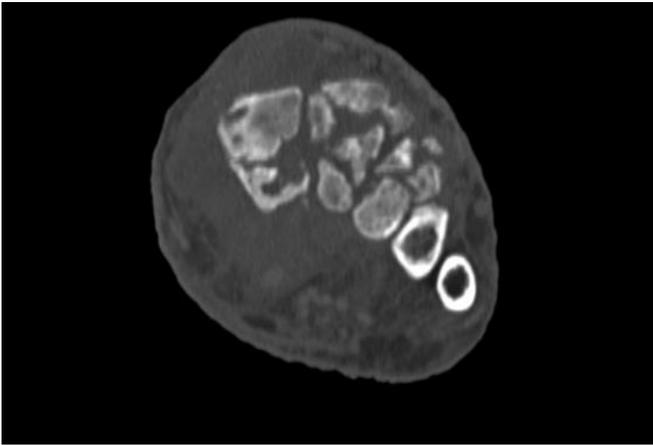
CT L foot without contrast demonstrating extensive deformity, destruction, dislocation and debris at the bases of the first through third metatarsals.
